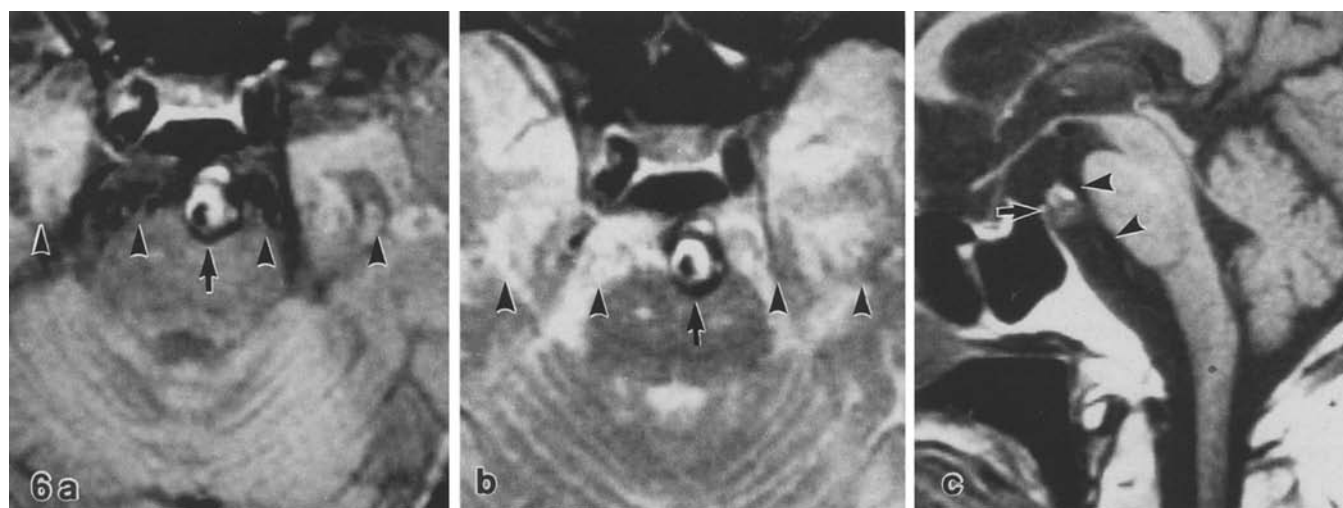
a-c. Case 3. PD-weighted (a) and T2-weighted (b) axial images showing a circular hyperintensity surrounded by a hypointense rim (arrows). A crescent-shaped hyperintensity is located ventral to the lesion. Phase-encoding artifacts (flow artifacts, arrowheads) indicate that the central hypointensity is flowing blood, that is true lumen of the dissecting aneurysm. T1-weighted sagittal image (c) demonstrating a mixed-intense oval lesion (arrow) located ventral to the arterial lumen (signal-void linear structure, arrowheads)
